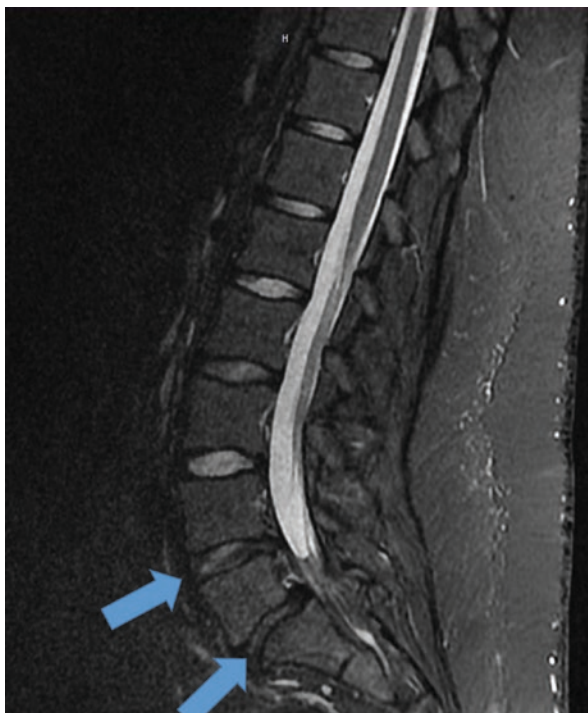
Lateral lumbar MRI; degenerative disc findings associated with L4-L5 and L5-S1 discs (*arrows*). No spinal canal or foraminal narrowing associated with this level. Notice the mild forward slip of L5 on S1, which on a supine film or supine MRI is often less noticeable than seen on the standing radiograph
